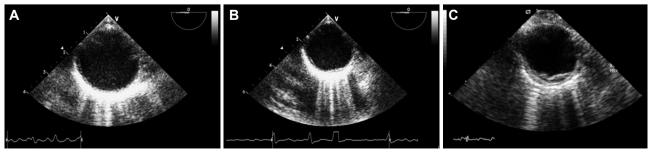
Short-axis transesophageal echocardiographic views of the thoracic aorta showing aortic plaque thickness. A: plaques with <1 mm thickness. B: 2.2 mm plaque thickness (1-3.9 mm). C: 7 mm plaque thickness (≥4 mm).
